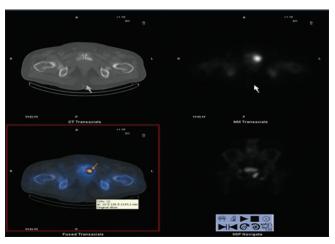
Single-photon emission computerized tomography/computed tomography image of the pelvic region revealing osteoblastic lesion in the superior rami of the pubic bone with subtle sclerotic changes
